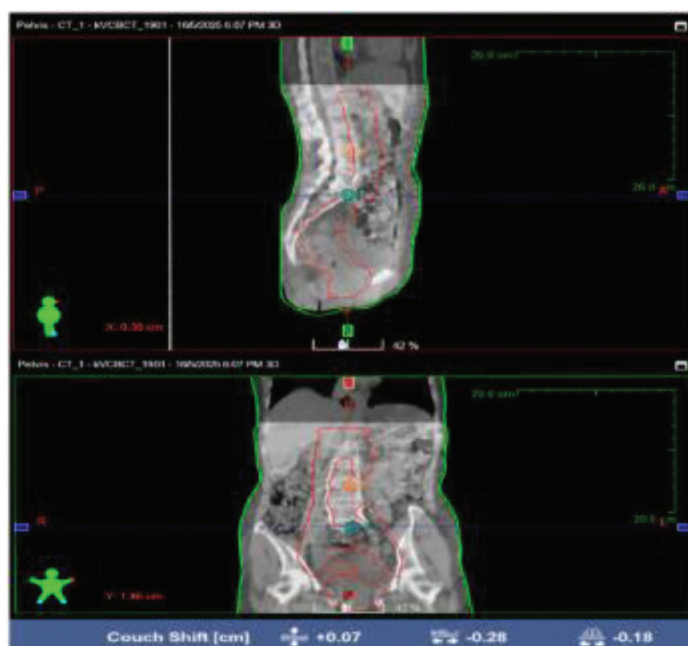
KV-CBCT and planning CT image registration for patient setup verification.
